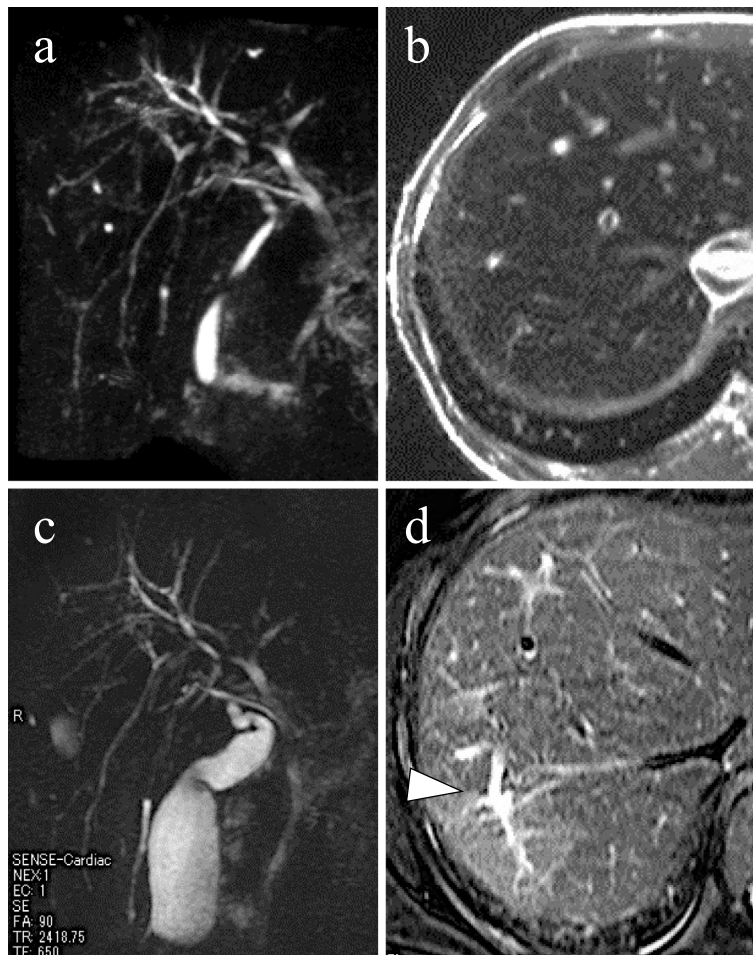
Magnetic resonance imaging shows an intrahepatic bile duct stricture and pruned-tree appearance, mainly in the anterior segment of the right hepatic lobe (a, b). Magnetic resonance imaging at 15 months after the initiation of cART shows further focal dilatation in the intrahepatic bile duct (arrowhead) (c, d).
